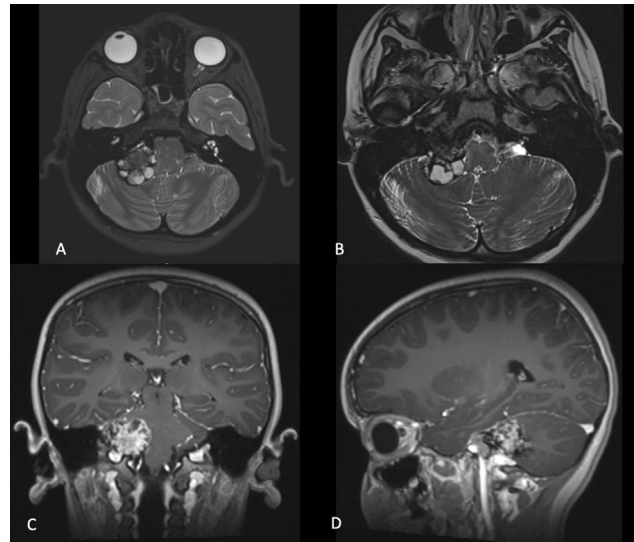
Preoperative MRI showing a right jugular foramen heterogeneous mass with solid and cystic components that appear hypervascular. (A) Axial T2. (B) Axial balanced fast field echo. (C) Coronal T1 with contrast. (D) Sagittal T1 with contrast.
